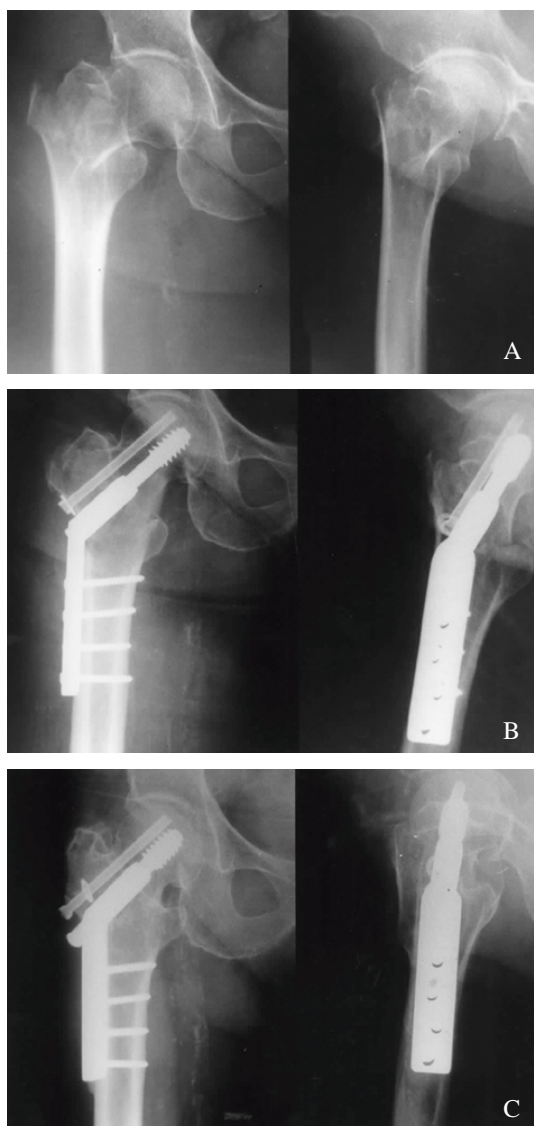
radiograph of a 89 years old female shows Jensen type III trochanteric fracture of the femur.
